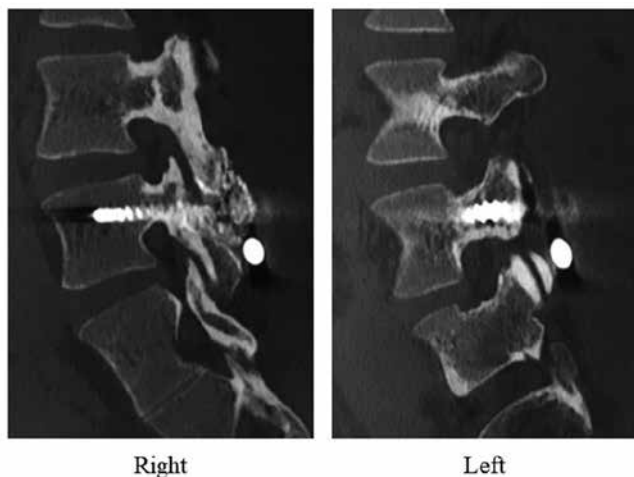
Sagittal CT scans 6 months after surgery confirm bone fusion at both the pedicle and pars fractures.
